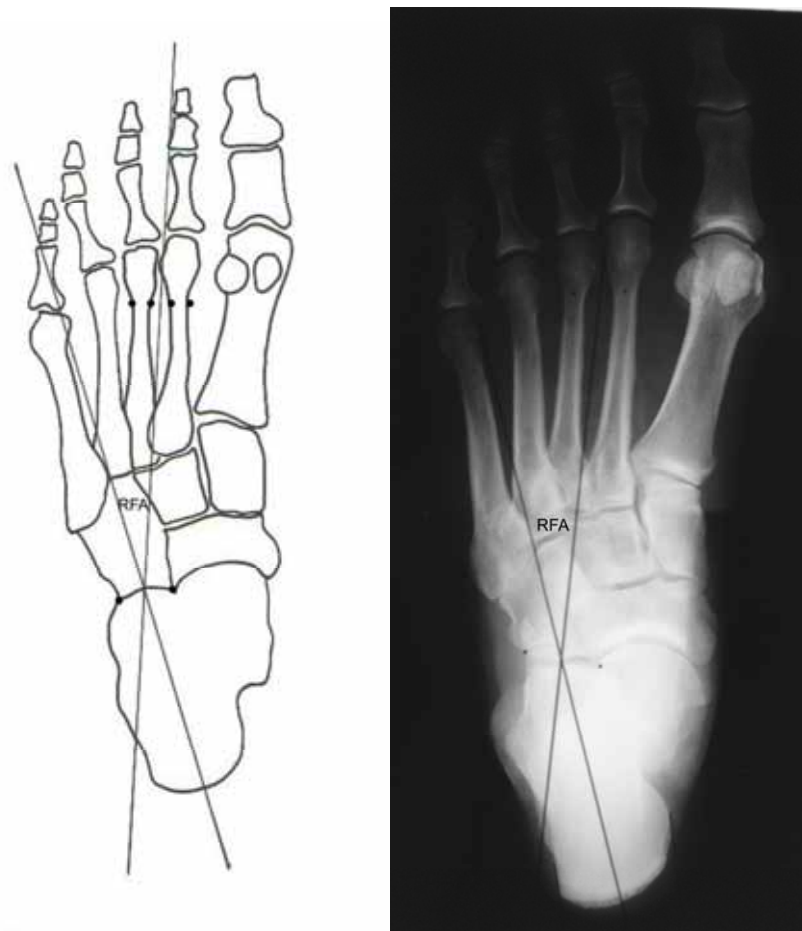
Measurement of RFA angle using a weight bearing COMP radiograph (adapted from Taranto et al, 2004)⁷
